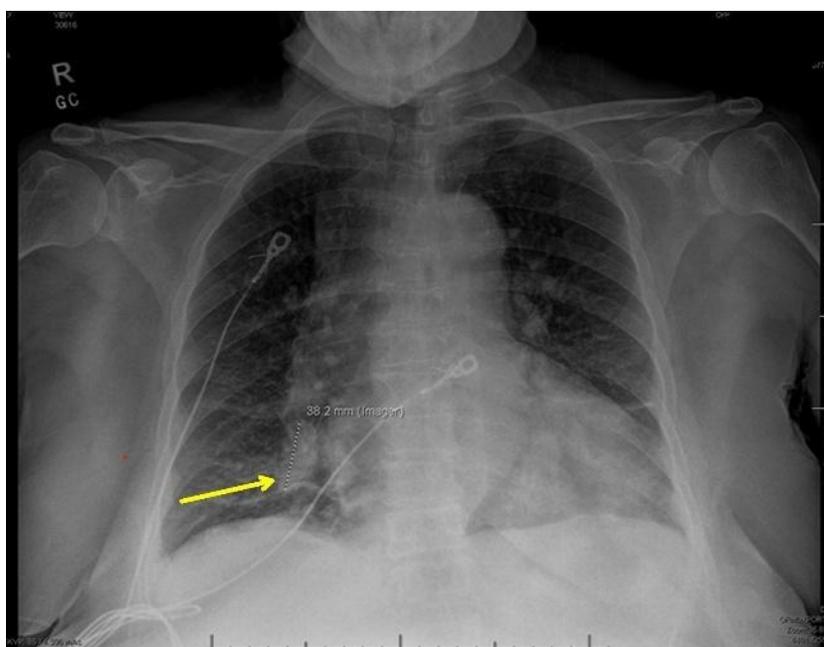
Chest X-ray before surgery. A 3.8 cm ovoid mass in the right middle lobe is at the yellow arrow. Linear atelectatic changes in both lower lobes. Stable cardiomegaly with mild vascular congestion.
